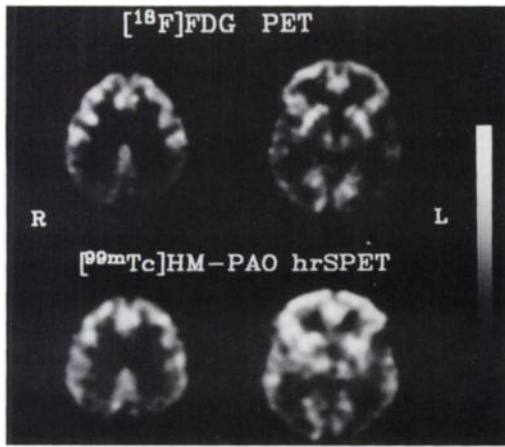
Cerebral glucose metabolism using PET with [¹⁸F]FDG (top row) and perfusion using high-resolution SPECT with ^{99m}Tc-HMPAO respectively (bottom row) in one patient with probable AD (Patient 3, Table 1). Two tomographic levels parallel to the orbito-meatal line through the mid and cranial parts of the brain are represented. Images are displayed with respect to the maximum value of each study (PET and SPECT). Both studies show marked reduction of metabolism in the temporal and parietal cortices, more marked in the right side. Note the preservation of metabolism and perfusion in the calcarine cortex and in the basal ganglia, which are well depicted in both studies.
